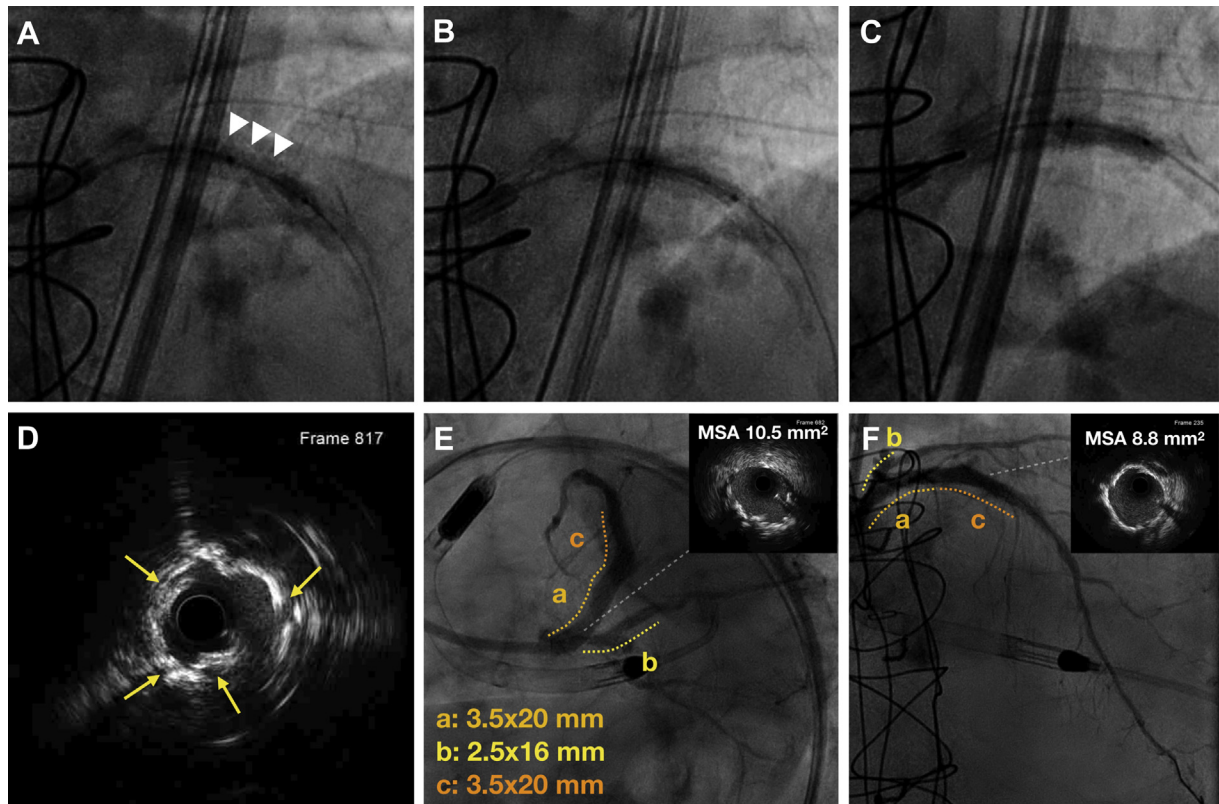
(A) Inadequate 3.0-mm noncompliant balloon expansion on the proximal left anterior descending (LAD; arrowheads). (B) Intravascular lithotripsy (IVL) with 3.5-mm Shockwave balloon: Acceptable balloon expansion is achieved after 60 pulses of IVL. (C) Full expansion of a 3.5-mm scoring balloon. (D) Intravascular ultrasound (IVUS) showing adequate plaque modification (arrows point at calcium fractures). (E, F) Good final angiographic and IVUS result after implantation of 2 drug-eluting stents on the left main-LAD and proximal circumflex-first marginal branch (DK crush), and another on the proximal LAD. MSA, minimal stent area.
